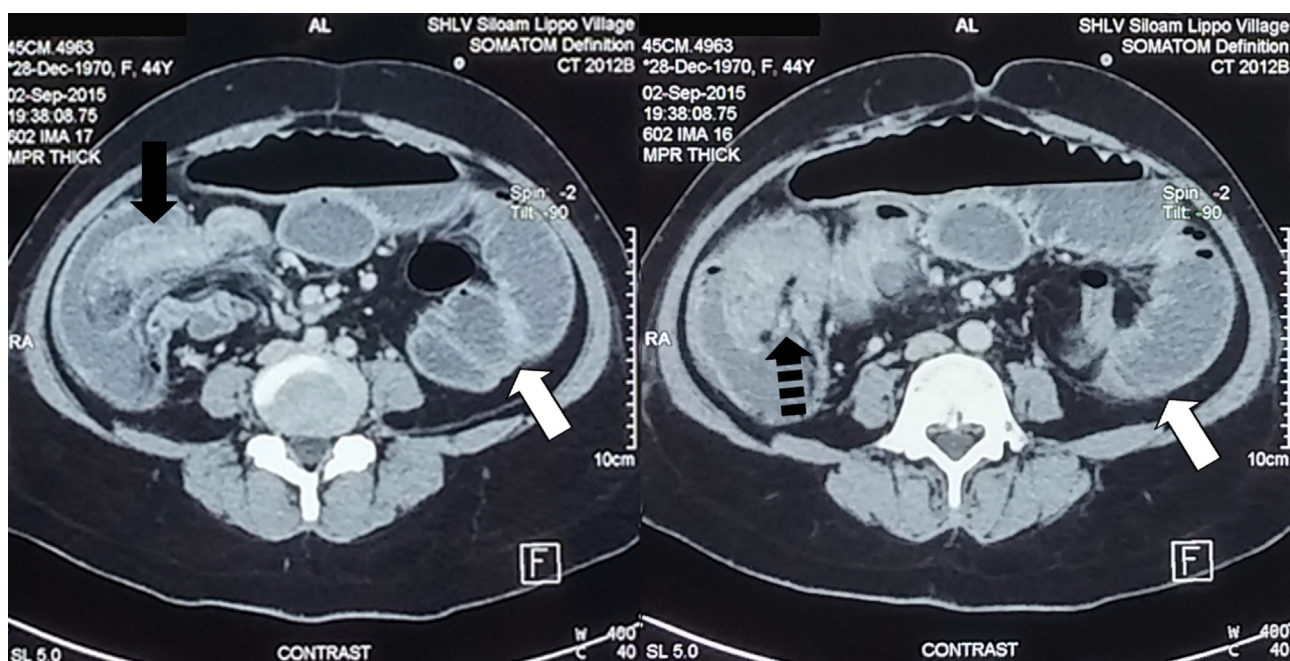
Computed tomography scan of the abdomen showed dilated small intestines with no thickening of the walls (white arrow), with image of intestine within intestine (black arrow) and a leading point (dashed arrow) on the region of ileo-colica, suggestive of intussusception. No signs of ischemia and lymphadenopathy of the intestines were found.
